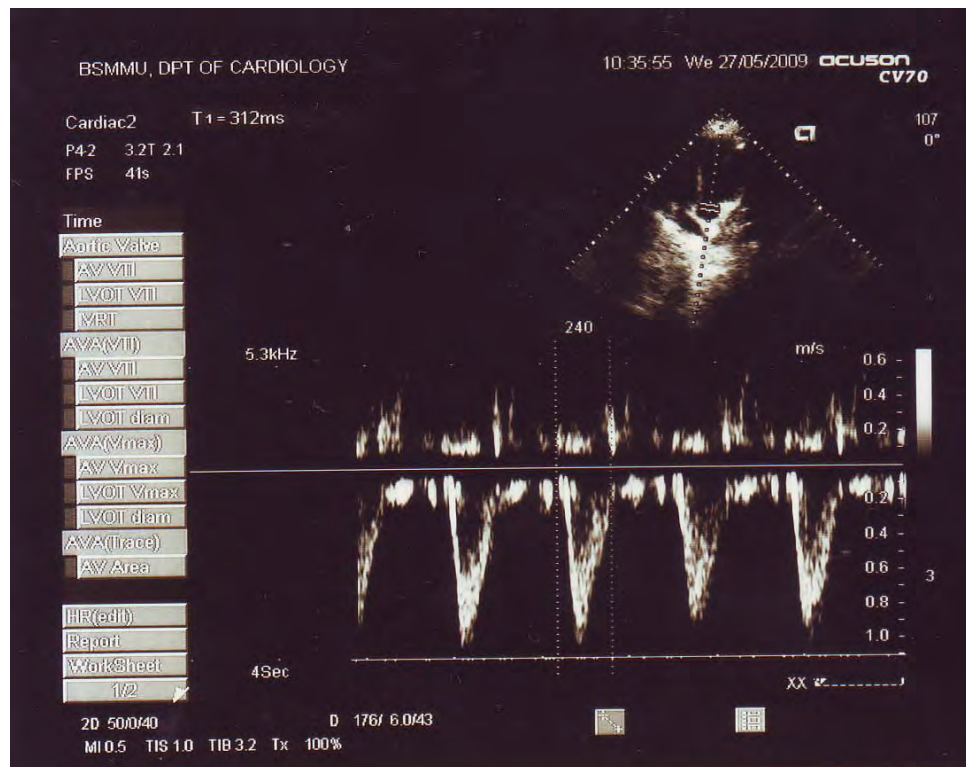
Normal Peak aortic velocity in spectral analysis of Doppler Echocardiography.
